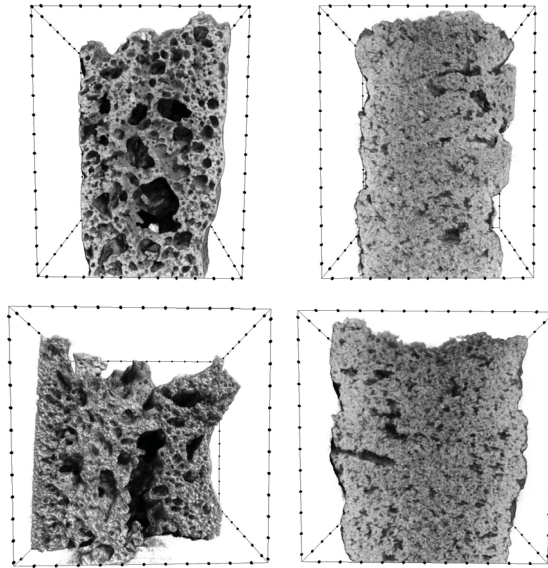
X-Ray μ -CT pictures of DF ISM IDM (top left), DF 50% MTL IDM (top right), DF ISM THL (bottom left) and DF 50% MTL THL (bottom right) using VitE as surfactant.
